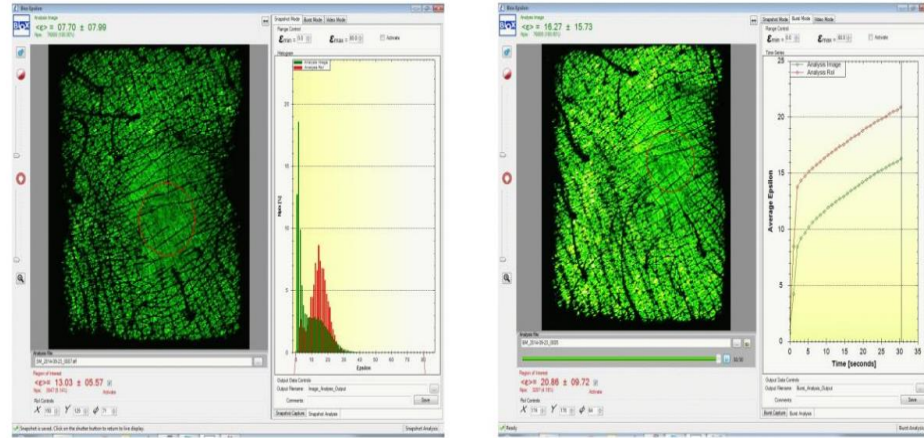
Ultrasound Image (Biox Systems Ltd, 2014)
